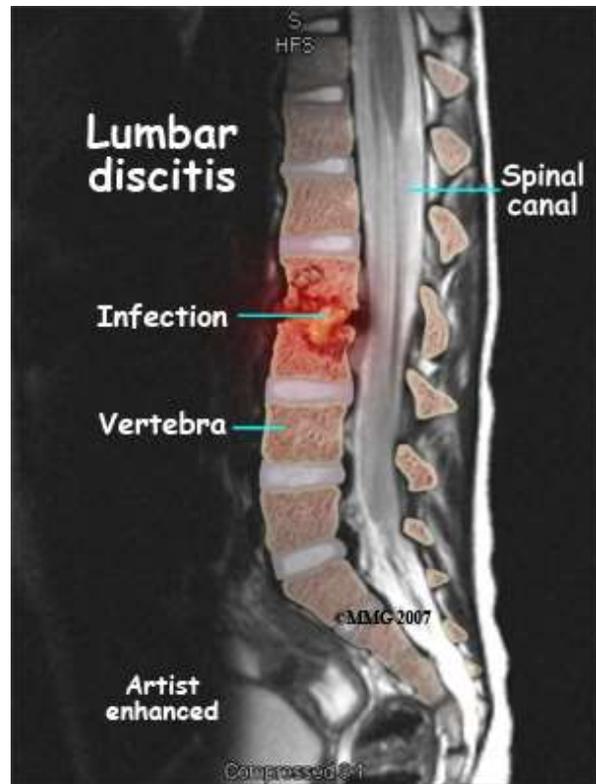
An abnormal MRI showing lumbar discitis (copied online)
